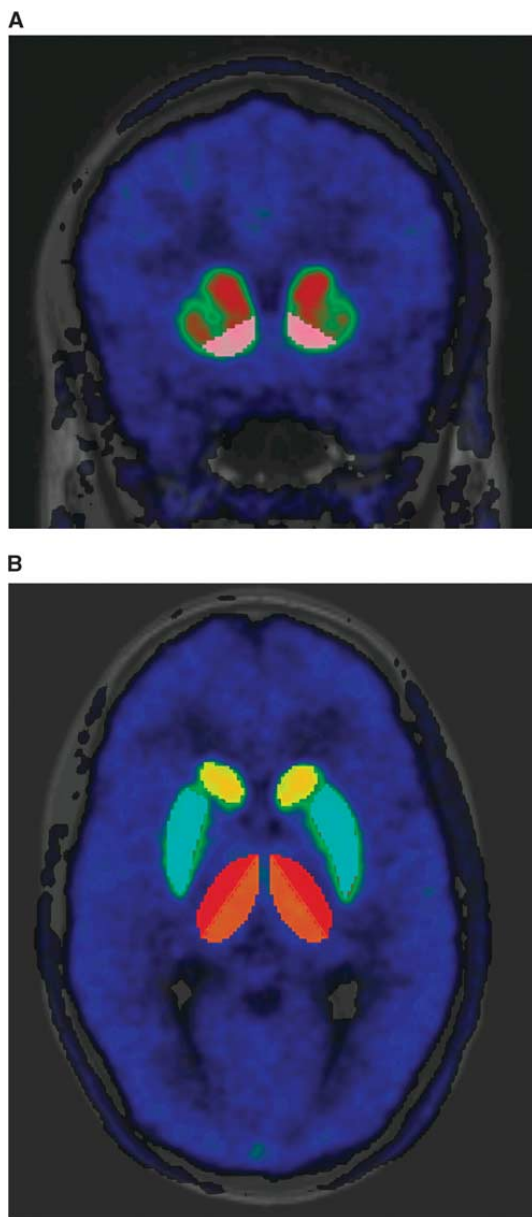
Activity distribution of [¹¹C]raclopride in coronal view (A) and in axial plane (B). A mean image of positron emission tomography (PET)-to-PET coregistered summed PET images is overlaid on a T1-weighted magnetic resonance image of one subject at the level of the striatum. Regions of interest are defined on the caudatus, putamen, thalamus, and the ventral striatum.
